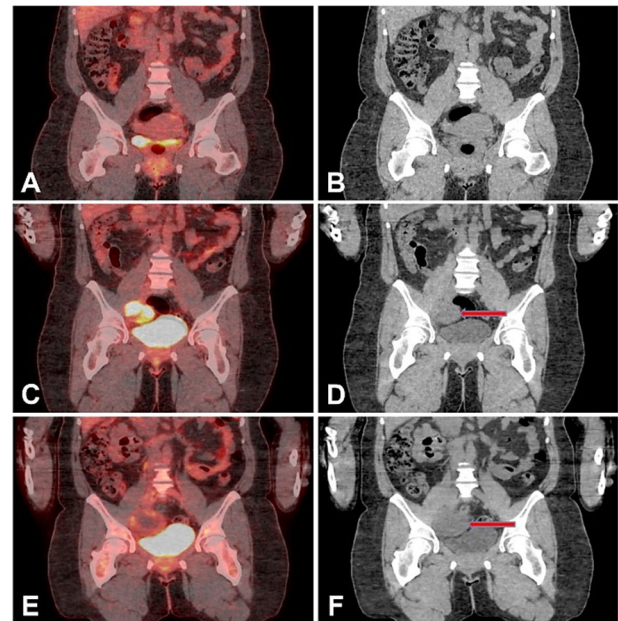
Coronal and CT images of ^{18}F -FDG PET/CT scans at three different time points: initial diagnosis (A and B), at the time of local recurrence (C and D) showing an intense hypermetabolic right pelvic lymph node mass, and after two cycles of CHT (E and F) showing a partial metabolic response ($\Delta\text{SUV}_{\text{max}}$ -65%), but with an increase in volume of the right pelvic mass on CT images probably due to necrotic tissue (red arrow on D and F images). ^{18}F -FDG: ^{18}F Fluorine-fluorodeoxyglucose; CHT: Chemotherapy; CT: Computed tomography; PET: Positron emission tomography; SUV_{max} : Maximum standardized uptake value.
